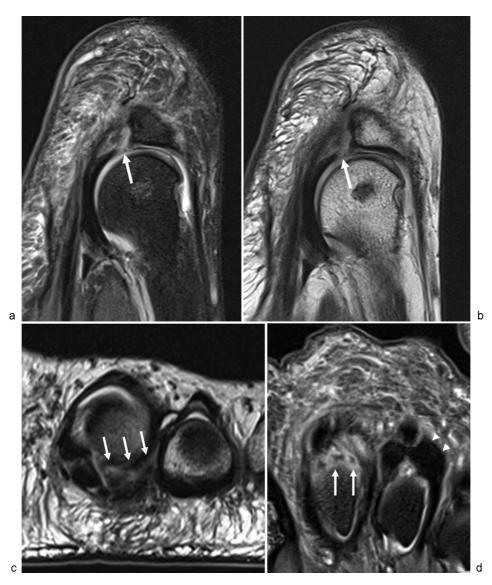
A 56-year-old woman presents with a 12-month history of second metatarsalgia and hammer toe deformity. (a) Sagittal fat-suppressed proton-density (PD) and (b) PD MR images demonstrate an extensive tear of the lateral plantar plate of the second MTP joint with transverse and longitudinal components (arrows). (c) Short-axis T2 and (d) long-axis fat-suppressed PD MR images demonstrate the tear extends transversely over > 50% of the width of the plantar plate complex (arrows). Note the normal lateral plantar plate of the second MTP joint (arrowheads).
